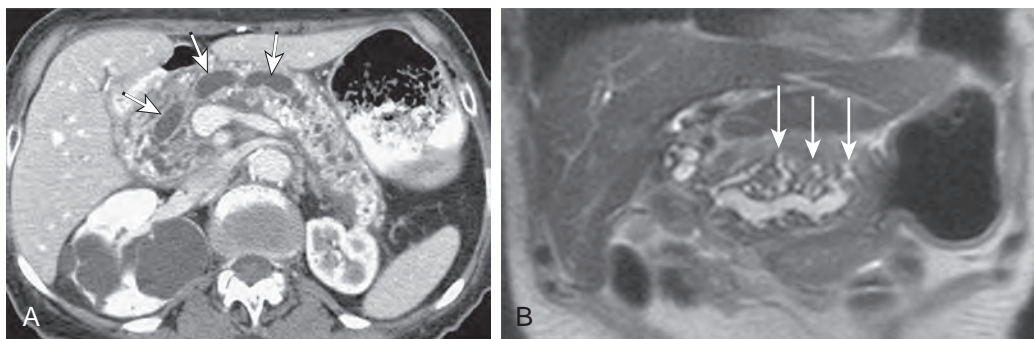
Chronic pancreatitis. A. Axial contrast-enhanced MDCT image shows diffuse calcifications in the pancreas with a dilated main pancreatic duct (arrows) measuring 9 mm and dilated side branches. B. Coronal T2-weighted MR image shows the dilated pancreatic duct and secondary radicles (arrows) associated with chronic pancreatitis. (B from Miller FH, Keppke AL, Wadhwa A, et al: MRI of pancreatitis and its complications: Part 2, chronic pancreatitis. *AJR Am J Roentgenol* 183:1645–1652, 2004. Reprinted with permission from the American Journal of Roentgenology.)
